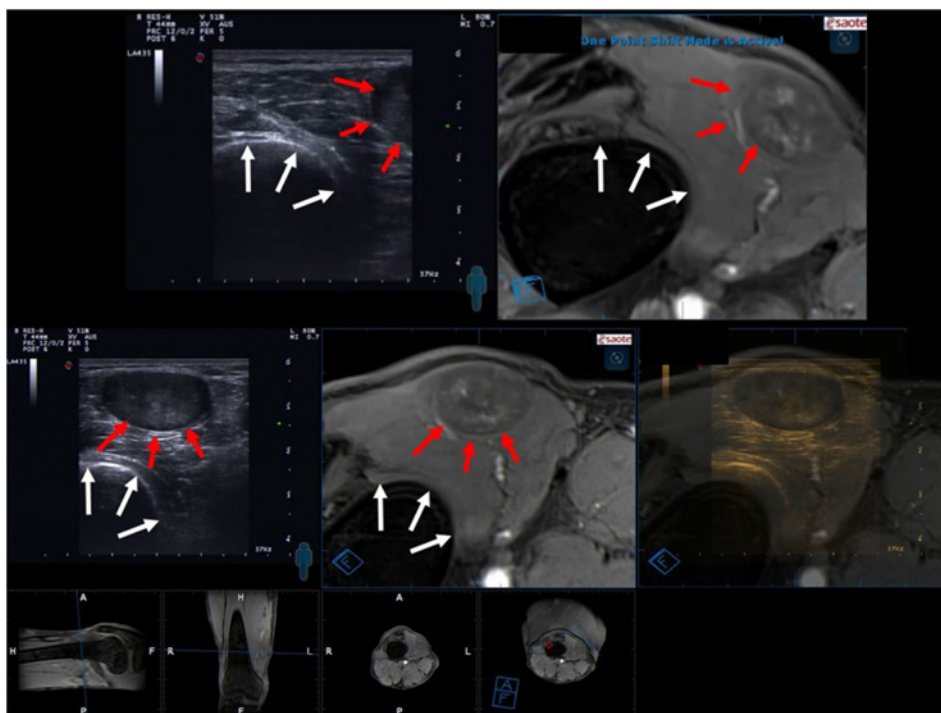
Top row: Cross-sectional insonation of the left upper leg in a patient with a neurofibromatosis and corresponding MRI. Top left: ultrasound image with delineation of the femoral bone (white arrows) and a large neurofibroma (red arrows). Middle left: B-mode image of the same lesion centered to the image. Middle: corresponding cross-sectional MRI image. Middle right: overlay image of both imaging modalities, demonstrating good congruence of ultrasound and MR image.
